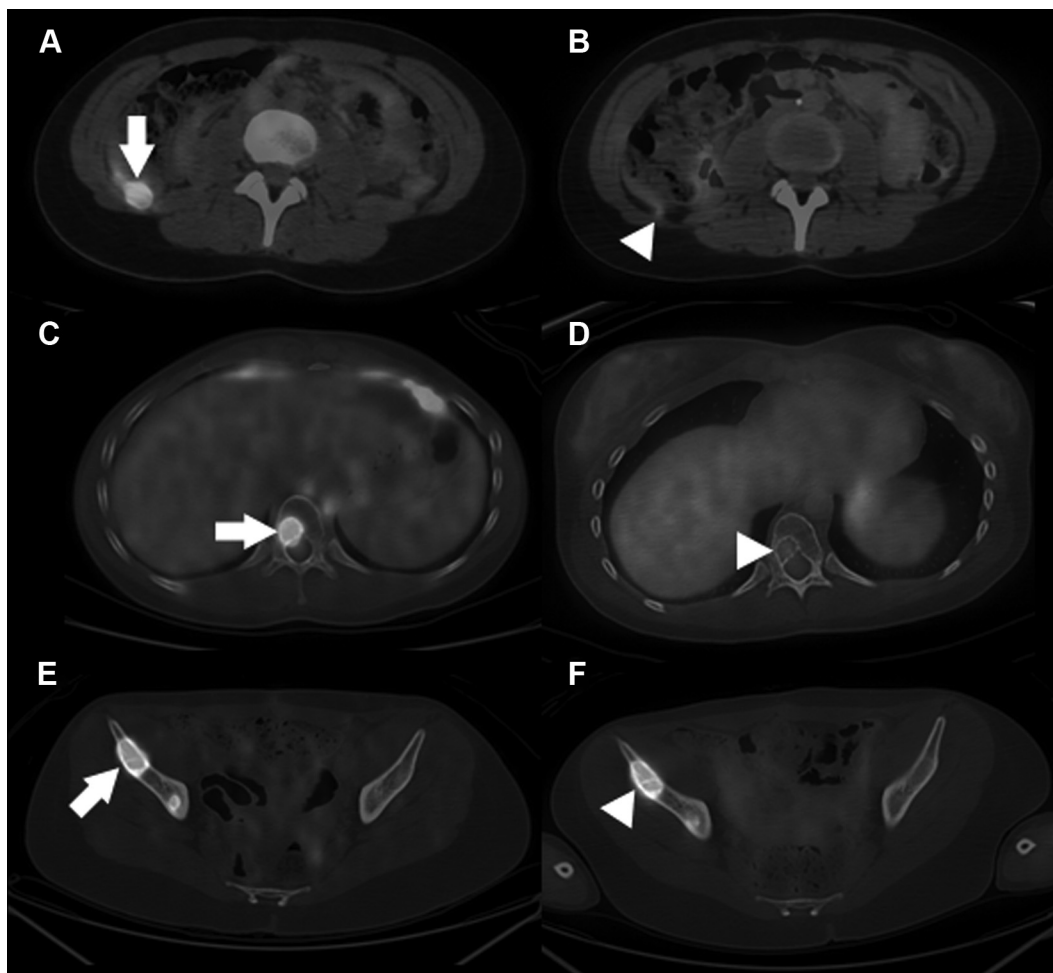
Positive response to sunitinib and rapamycin. A patient with both bone and soft-tissue sites of metastatic disease was treated with sunitinib. The results of two FDG-PET/CT studies are shown, obtained 36 months apart. A and B, A soft-tissue metastasis in the right flank decreased in intensity from an SUV of 17.5 before treatment to 2.7 after treatment; C and D, a lytic bone metastasis in the T11 vertebral body decreased in intensity from an SUV of 21.6 to 2.1; E and F, a lytic bone metastasis in the right iliac bone, although persistently hypermetabolic, showed positive response with a decline in SUV from 37.6–14.6.
